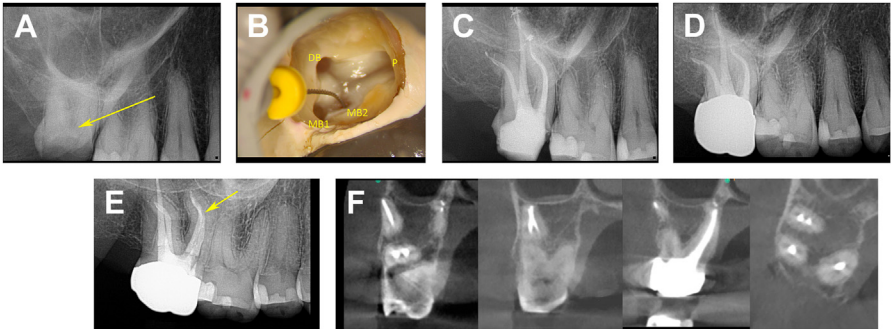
(A) Preoperative radiograph of a maxillary second molar (arrow) needing RCT. (B) Clinical microphotograph showing the identification and treatment of MB1 and MB2 (with file) canals (C) Immediate post-RCT radiograph showing 3-dimensional filling of complex branching root canal anatomy. (D) A 6-year post-treatment periapical radiograph showing stable completed RCT with a crown restoration. (E) A 6-year post-treatment off-angle radiograph showing the 2 MB canals merging at the apex (arrow). (F) Coronal and axial CBCT cuts showing complete root canal filling and normal periapical and periodontal osseous integrity.
